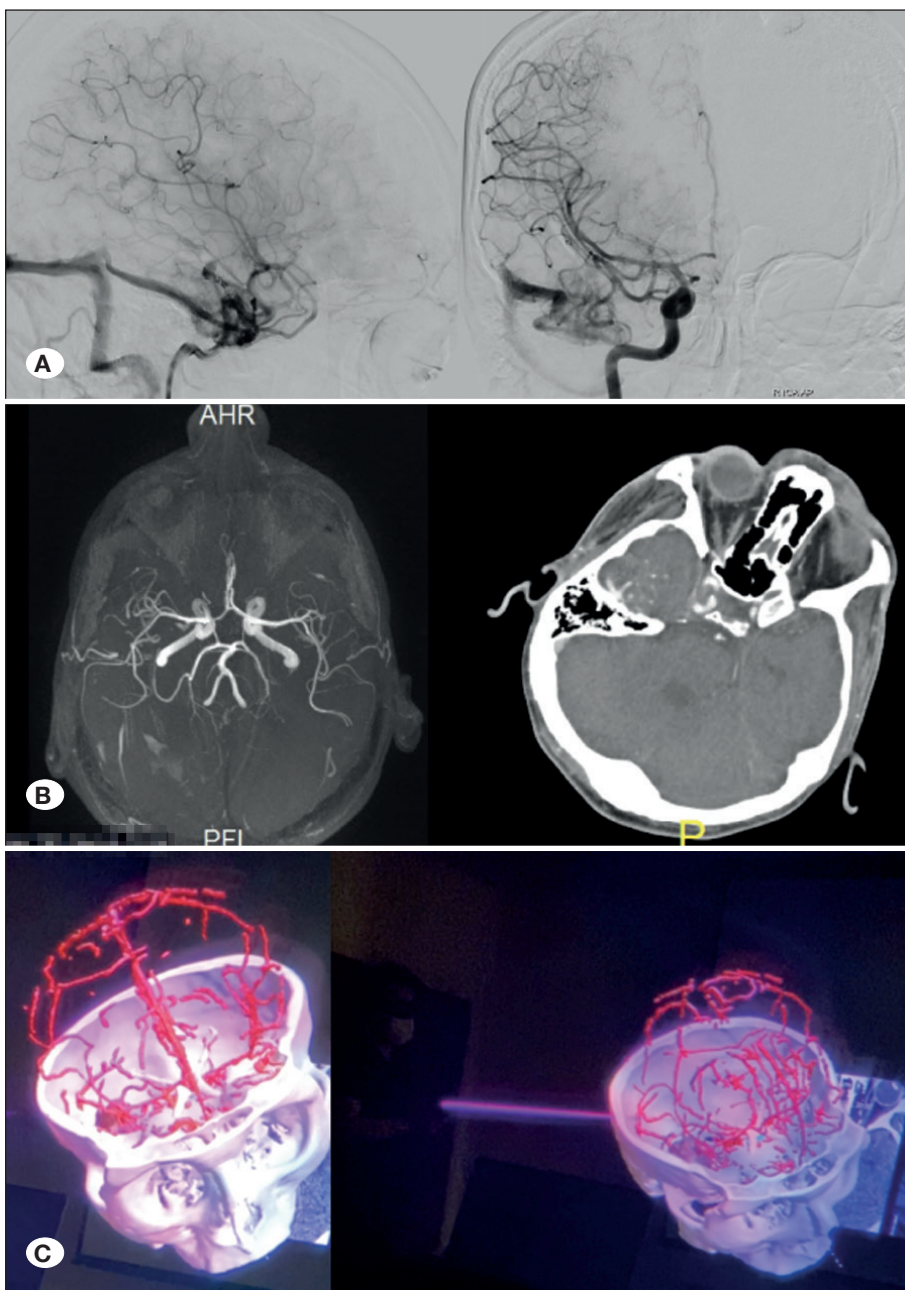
Preoperative imaging of the arteries. A) Digital subtraction angiography. B) Left: magnetic resonance angiography and right: CT angiography. C) Mixed reality images. Several techniques are used to evaluate the structure of a preoperative lesion, including its feeder and drainage veins. DSA: digital subtraction angiography; CT: computed tomography.
